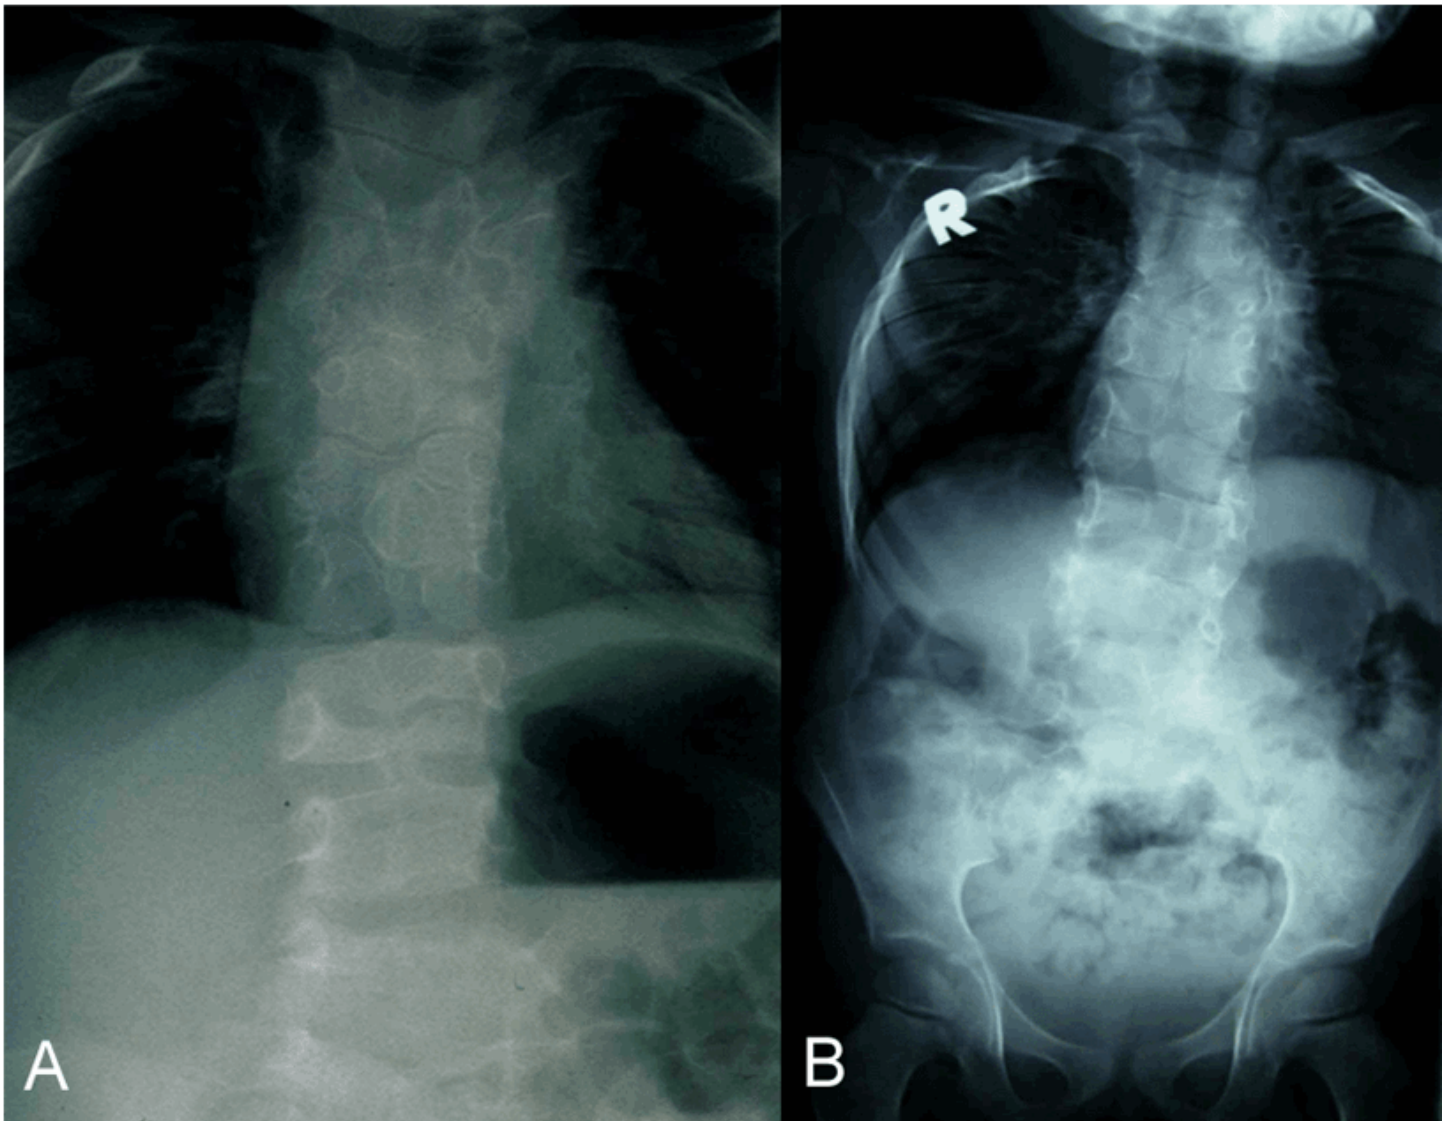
Radiographs of a child with *MESP2*-related SCDO. The generalized segmentation defects of the vertebrae show more angular features than is typical of *DLL3*-related SCDO.
